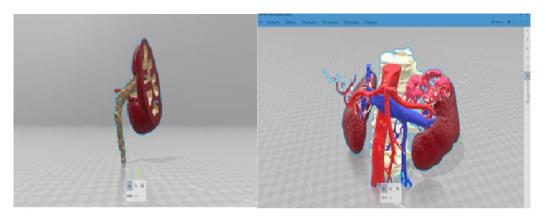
On the left is a healthy kidney, on the right is a CT scan showing signs of heterogeneous volume in the left kidney, 57.8x 37.3x 43.9mm in size
